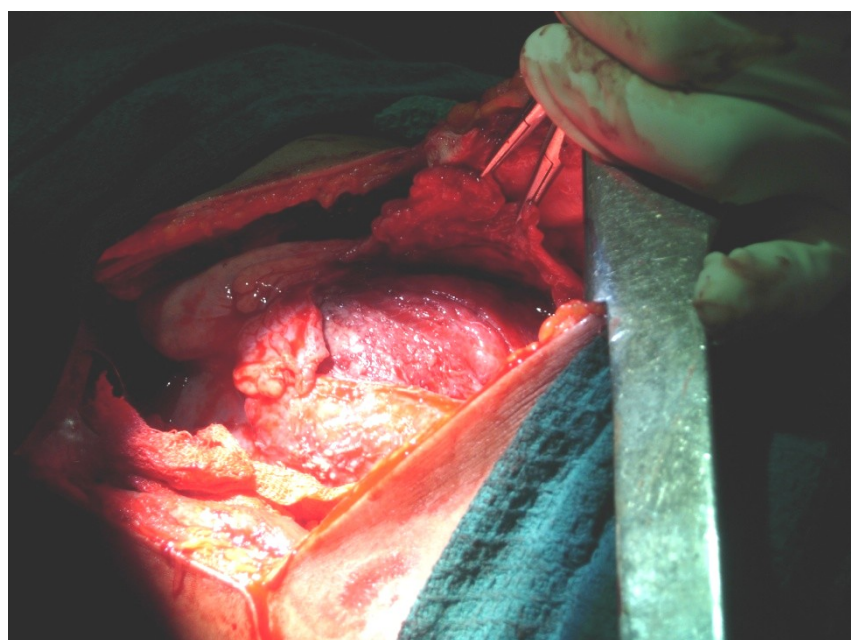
Excision of the thickened epicardium exposes the underlying myocardium Post pericardiectomy Echocardiography
